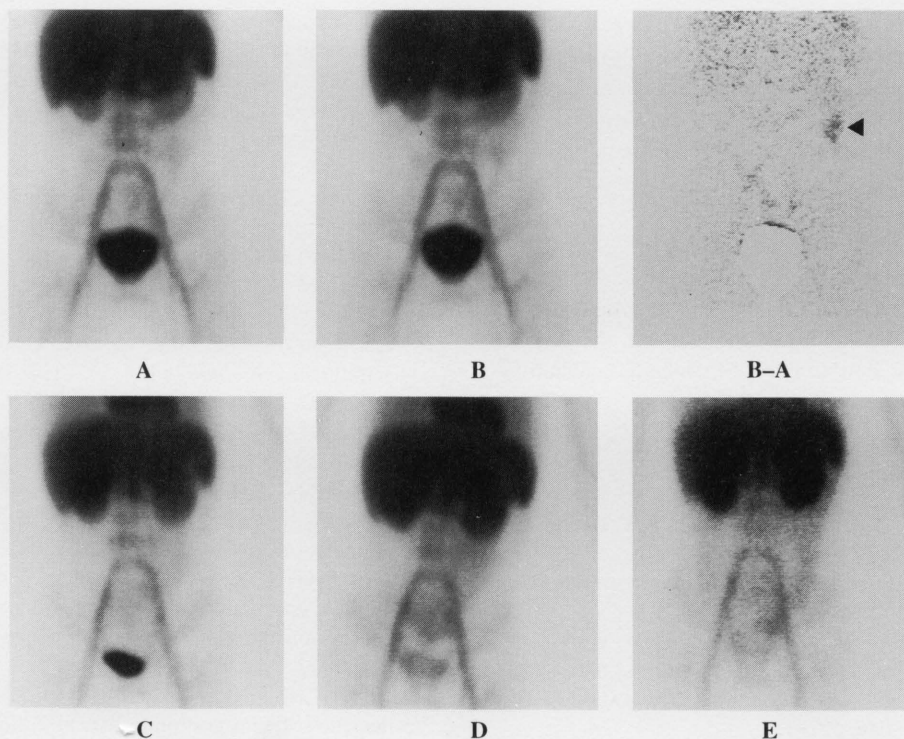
A 7-year-old girl with bleeding from small intestine due to ulcer. Conventional scintigrams with ^{99m}Tc -RBC at 30 (A), 35 (B), 60 (C), 210 (D) min and 20 (E) hr after injection. Abnormal diffuse accumulation of the tracer is seen in the LUQ and mid abdomen at 210 (D) min and is mainly localized in the descending colon at 20 (E) hr. A focal area of intense activity in the LUQ (arrow) is clearly seen on a subtraction scintigram (B-A) by 35–30 min images corresponding to the site of bleeding from small intestine.
